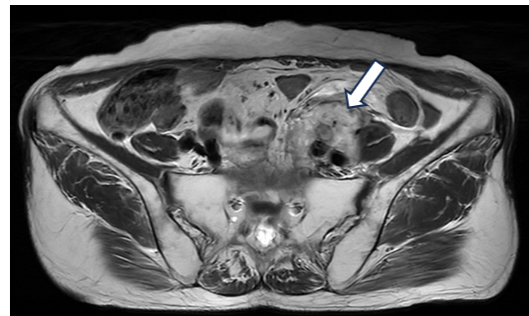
MRI T2W1 image.
